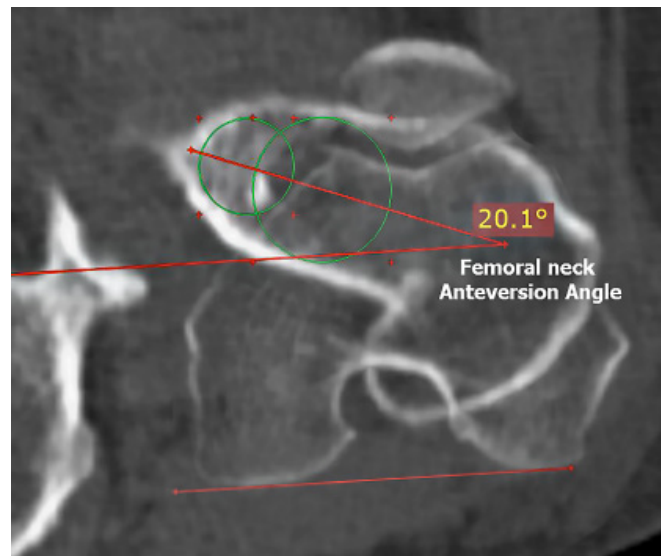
The Femoral neck anteversion angle (FA) in computed tomographic (CT) overlapped axial plane
